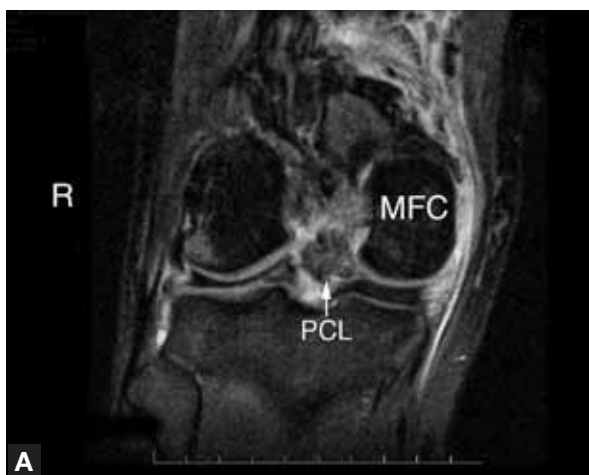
Coronal (A) and sagittal (B) magnetic resonance imaging shows complete soft-tissue separation of posterior cruciate ligament from its insertion at medial femoral condyle.
